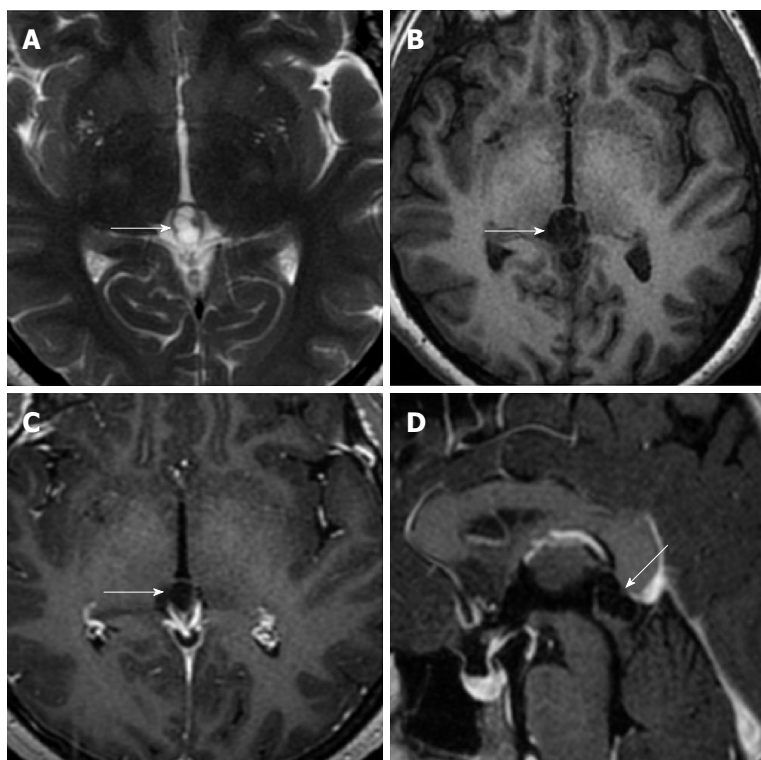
Thirty-three years old female patient with atypical pineal cyst (patient No. 53). Axial plane (A) T2 weighted (B) T1 weighted (C) contrast-enhanced (D) sagittal plane contrast-enhanced magnetic resonance imaging. A, B, C and D: Multilocular, lobule contoured, atypical pineal cyst is observed in pineal area (white arrows); C and D: Peripheral rim-like enhancement is shown (white arrows).
